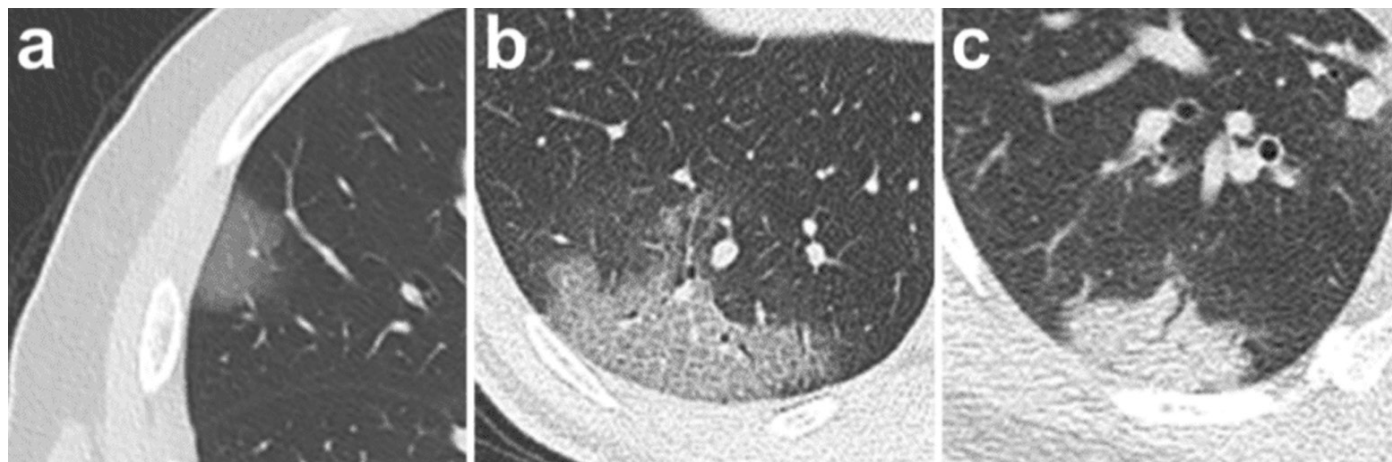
Thorax CT findings of COVID-19 pneumonia
